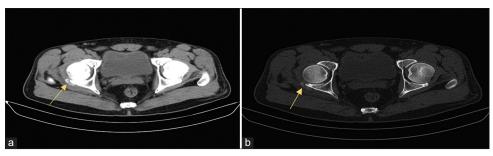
Axial CT scan soft-tissue window (a) and bone window (b) show nodular foci of calcium density (arrows), suggesting calcific deposits.
